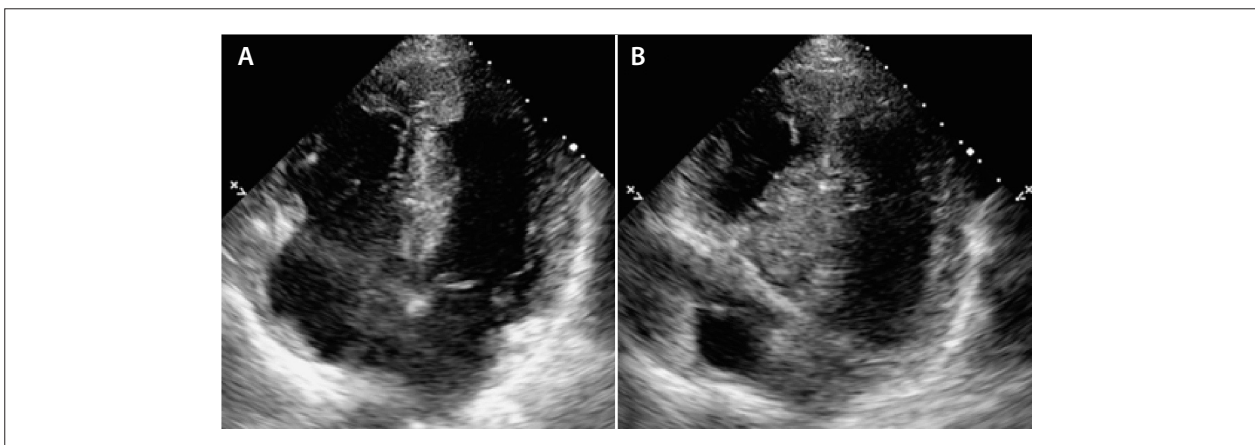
Echocardiography images. A and B: Multiple echogenic cardiac metastatic lesions in the right ventricle wall and apical and septal left ventricle wall.
